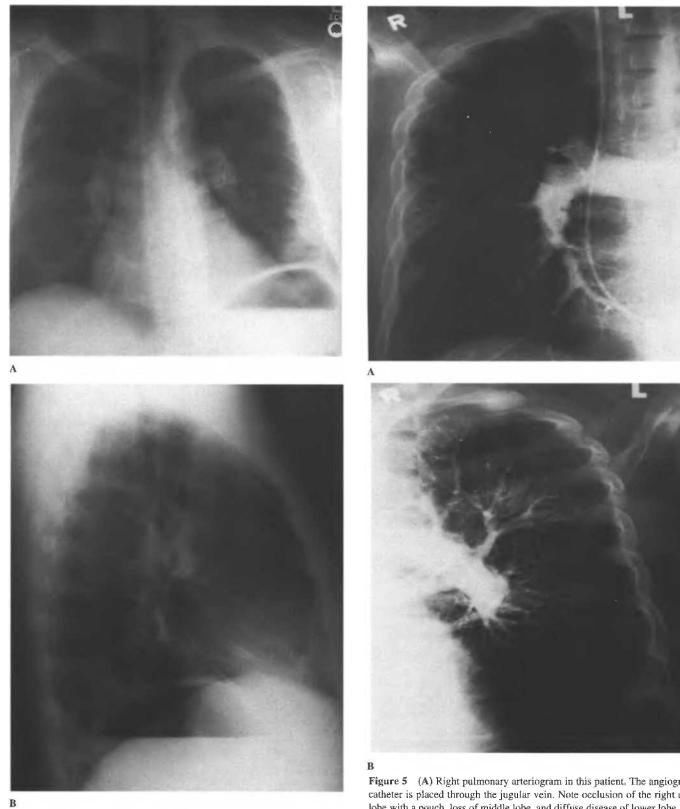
(A) PA chest X-ray of a patient with thromboembolic pulmonary hypertension. Compare with Figure 1. Right and left main pulmonary artery shadows are enlarged. (B) Lateral view in the same patient. Right ventricular enlargement
